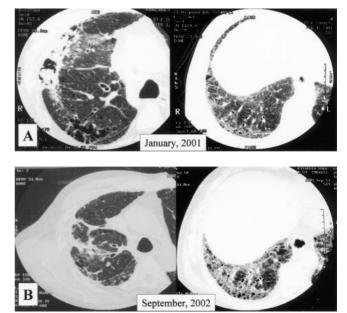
A: Chest HRCT scan in January 2001, showing a nodular shadow in the cavity lesion in the right S3, and reticulonodular, cystic, and ground-grass opacities in the bilateral lung fields, predominantly in the subpleural areas with honeycombing in the bilateral lower zones. B: Chest HRCT scan in September 2002, showing exacerbation of the opacities.
